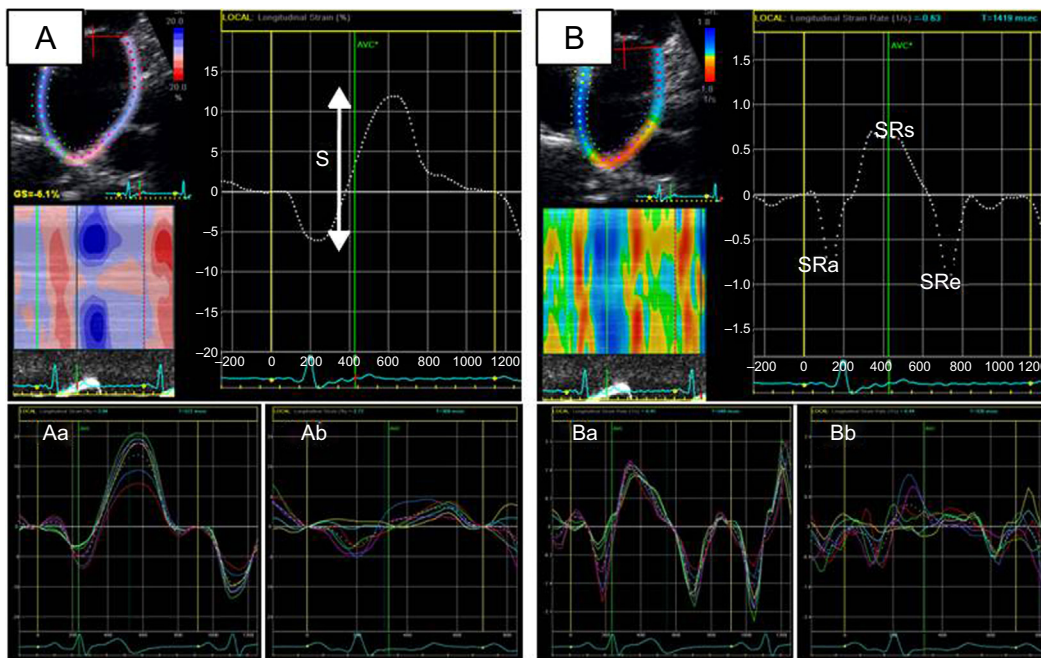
Study of left atrial function using myocardial deformation derived from 2-dimensional echocardiography (speckle-tracking strain). A: left atrial strain (a, patient with normal left atrial strain; b, patient with decreased left atrial strain). B: left atrial strain rate (a, patient with normal left atrial strain rate; b, patient with decreased left atrial strain rate). S, global left atrial strain; SRa, strain rate during atrial contraction (contractile function); SRc, strain rate during the early ventricular filling phase (conduit function); SRs, strain rate during ventricular systole (reservoir function).
